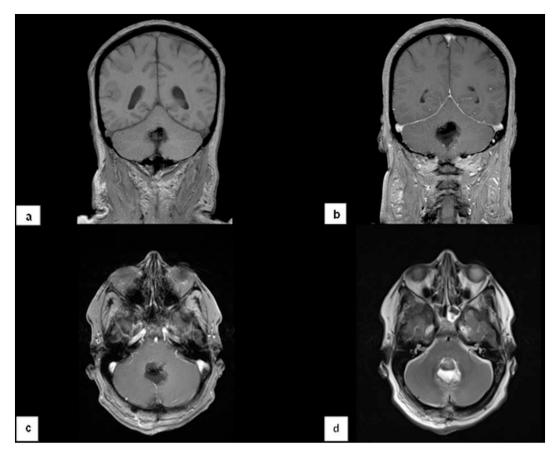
The early postoperative MRI scan shows no evidence of enhancing or non-enhancing residual tumour. A midline resection defect with some air inclusions can be appreciated.
